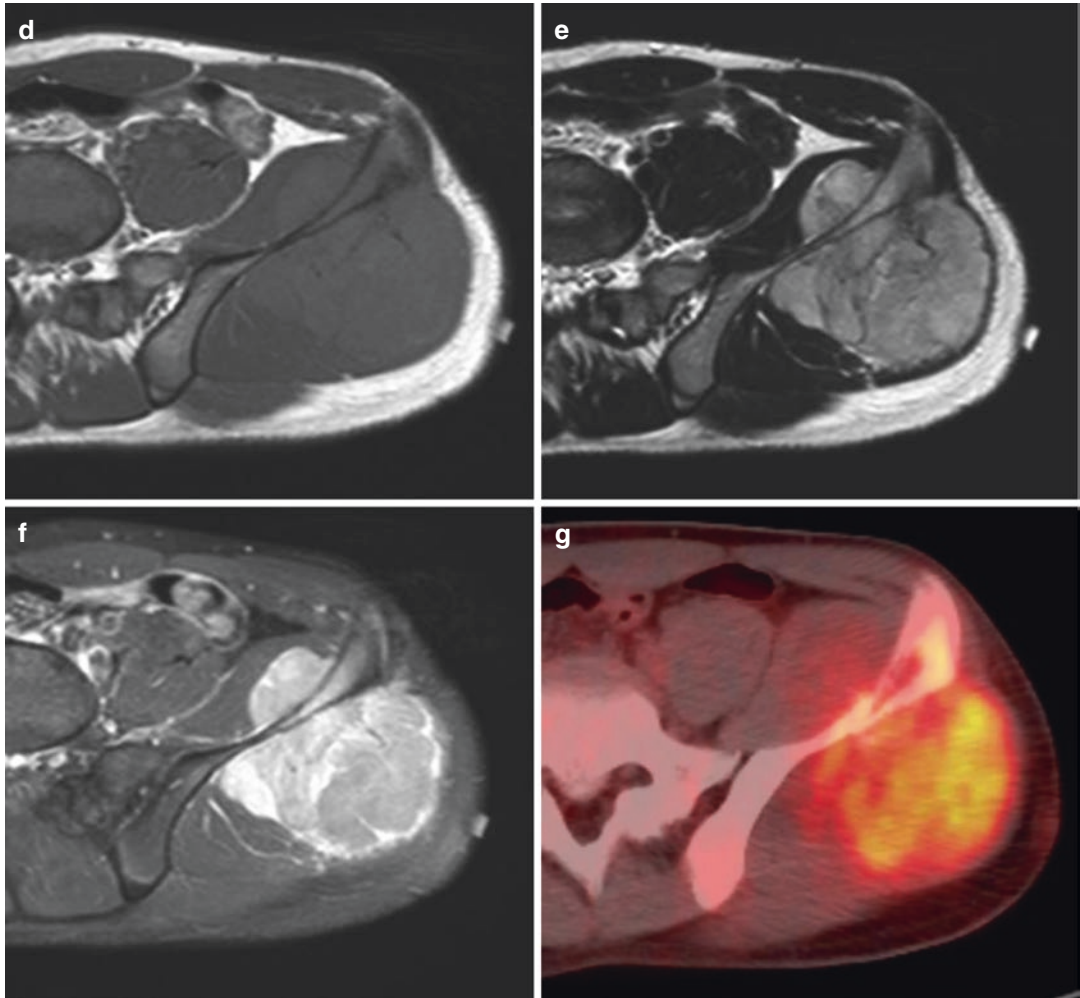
Ewing's sarcoma in the left ilium. (a) No significant bony abnormality is detected on the anteroposterior radiograph of the pelvis. (b) On bone scan, increased uptake is noted in the left ilium. (c) On axial CT image, an osteolytic lesion with subtle cortical fenestration (*arrow*). Subtle periosteal bone deposition is noted around the lesion (*arrowheads*). (d) Axial T1-weighted image, (e)
